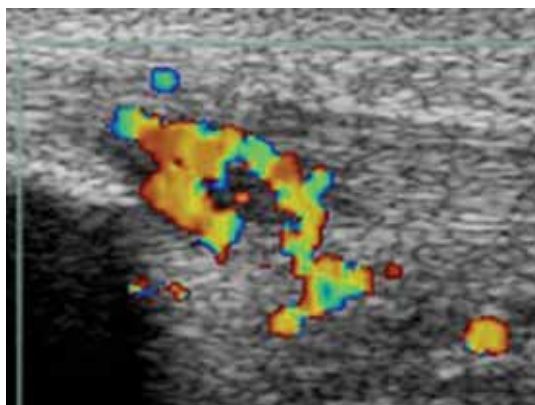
Colour Doppler ultrasound appearance showing increased blood flow in symptomatic tendinopathy.
